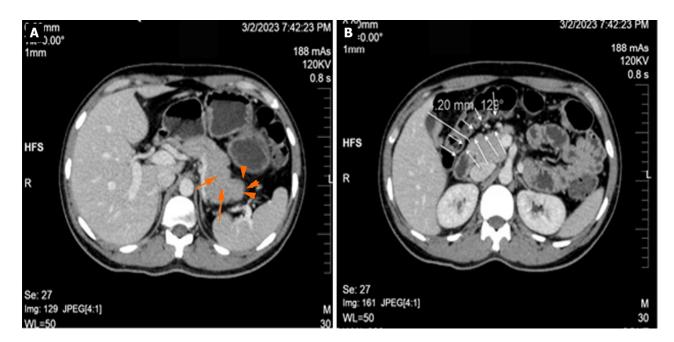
Computed tomography scan of the abdomen with contrast of a 34-year-old male patient who underwent a colonoscopy for 2months history of bleeding per rectum and significant involuntary weight loss and was found to have severe pan-ulcerative colitis and eventually developed acute pancreatitis hours after colonoscopy. The patient was admitted for 3-d and treated conservatively and experienced uneventful course. A: The pancreatic body and tail are homogenously enlarged (long arrows) with post-contrast enhancement, and faint peri-pancreatic fat stranding (short arrow); B: Shows the close proximity of the pancreas and the colon with distance of 4.2 mm (arrows). The close distance (4.2 mm) between the pancreas and colon wall may potentiate our assumption that direct mechanical trauma exerted to the colonic wall and transmitted to the pancreatic tissue is the precipitating cause of acute pancreatitis in the current case.
